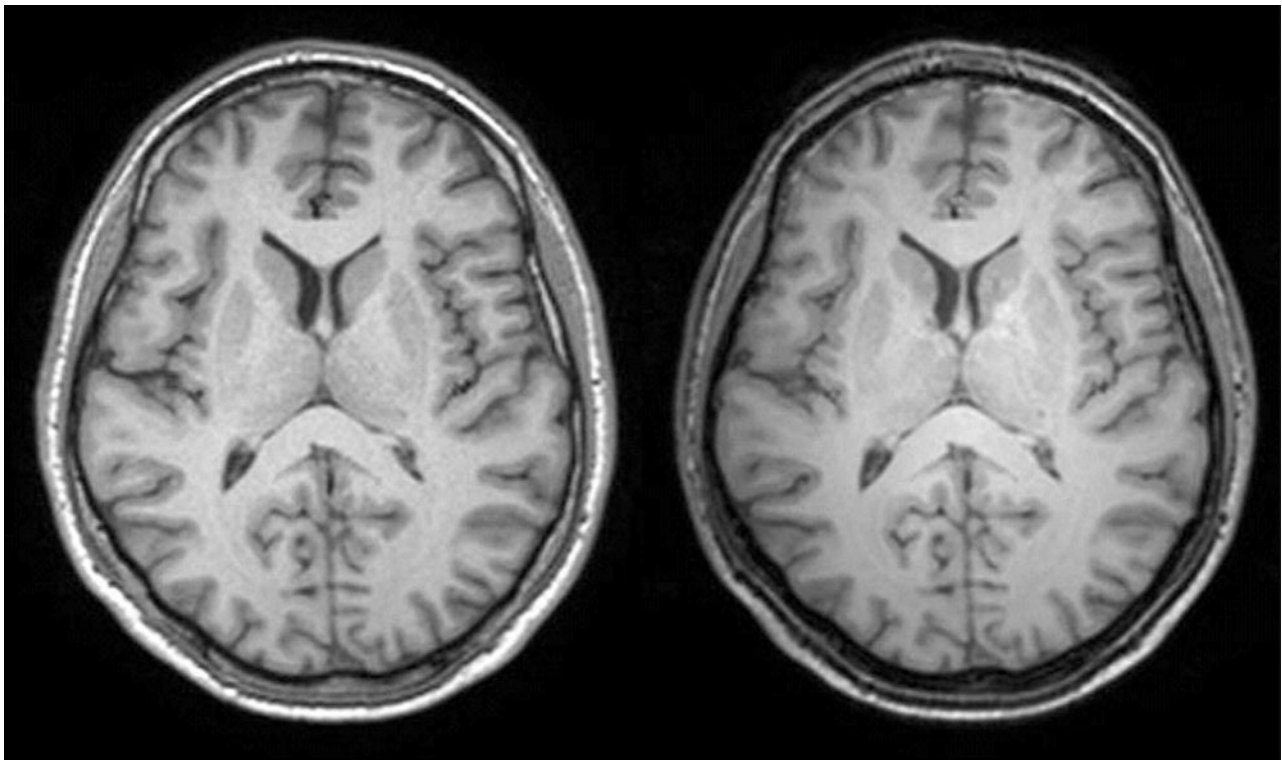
An example of 1.5 T versus 3 T MRI of the brain. It must be remembered that image acquisition is evolving along with image registration. With new imaging opportunities come new registration challenges. This pair of corresponding slices from rigidly registered brains acquired on two different scanners have exactly the same structure but appear subtly different, despite efforts to match the image acquisition schemes. The 3 T image has higher signal to noise ratio than the 1.5 T image but is also more prone to image artefacts, most obviously here in significant amounts of signal inhomogeneity across the brain (so-called “shading artefact”), and also flow artefacts from the carotid arteries. Registration algorithms driven by intensity information find it hard to differentiate between image differences caused by biological processes and those caused by details of the acquisition process. Image analysis studies that migrate from 1.5 T to 3 T scanners, or which involve aggregation of scans collected from scanners of different field strength are likely to have problems separating real effects from scanner-induced effects.
